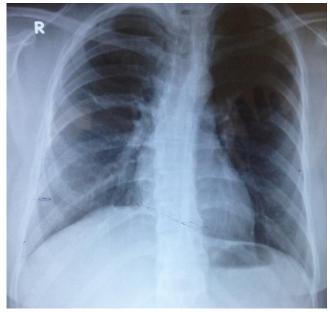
Postoperative chest x-ray shows normal appearance
